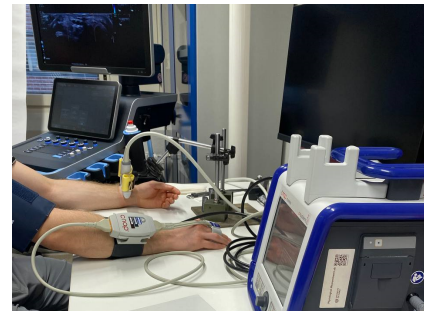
Setup used in the validation experiments. The ultrasound probe was oriented to the radial artery of the left wrist by a custom made probe holder. The CNAP device was attached to the index and middle fingers of the right hand.
